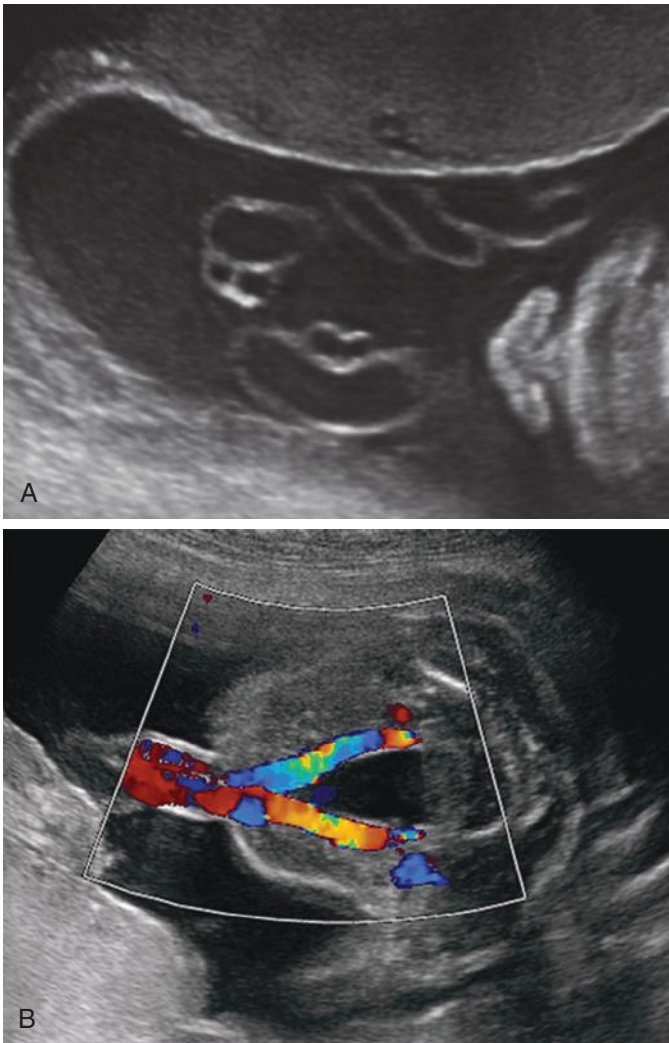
A, Normal three-vessel umbilical cord in cross section, comprising two umbilical arteries and a larger umbilical vein. B, Color Doppler image of the fetal bladder encircled by the two umbilical arteries, which are a continuation of the superior vesical arteries, confirms that the cord has three vessels.
